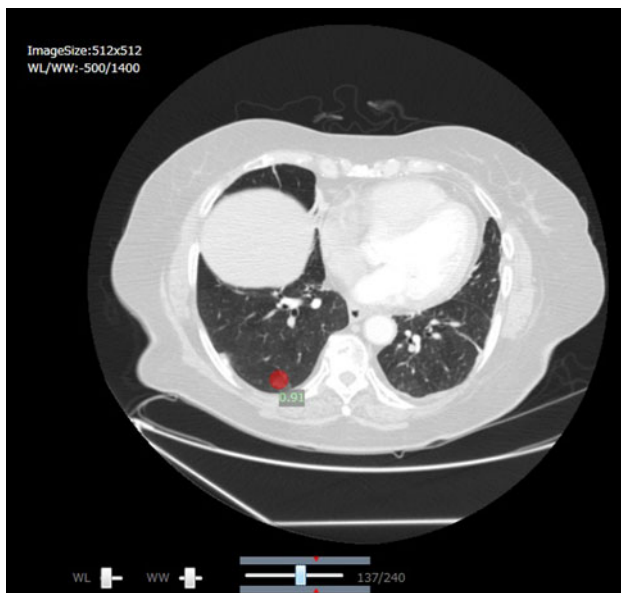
Screen shot of the computer interface for viewing CT images with stack mode. All slice images could be viewed with cine mode by use of a *slide bar* located at the *bottom* of images. Ratings with location pointed out were made with the same manner as that for FROC study shown in Fig. 3. When the observer marked a possible lesion on the slice image, the location of the slice image among a series of stacked slice images was shown with a *red mark* at the *top* and *bottom* of the *slide bar*
